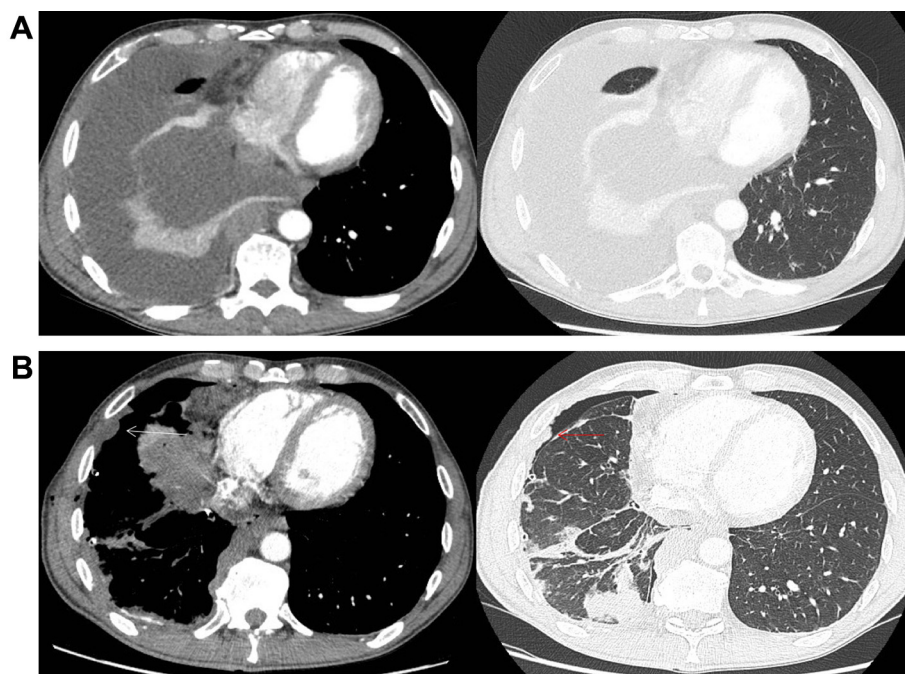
A, Axial CT image showing large pleural effusion and atelectatic lung, without detectable pleural nodularity. B, The same patient after drainage. Trapped lung reveals significant parietal pleural nodularity (arrows) that was not apparent prior to drainage.
